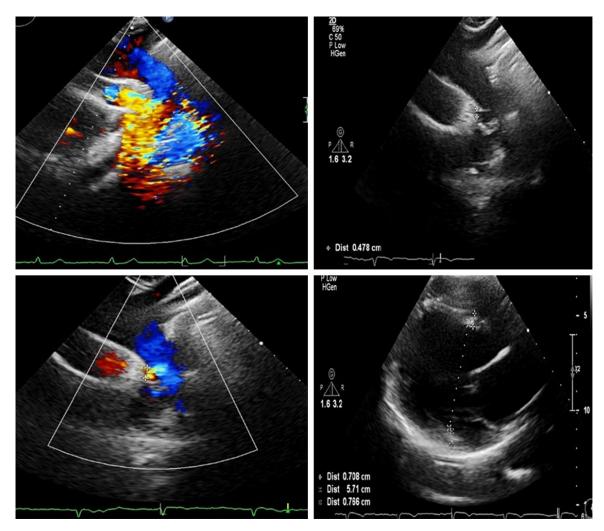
PDA with dilated LV in echocardiography.
